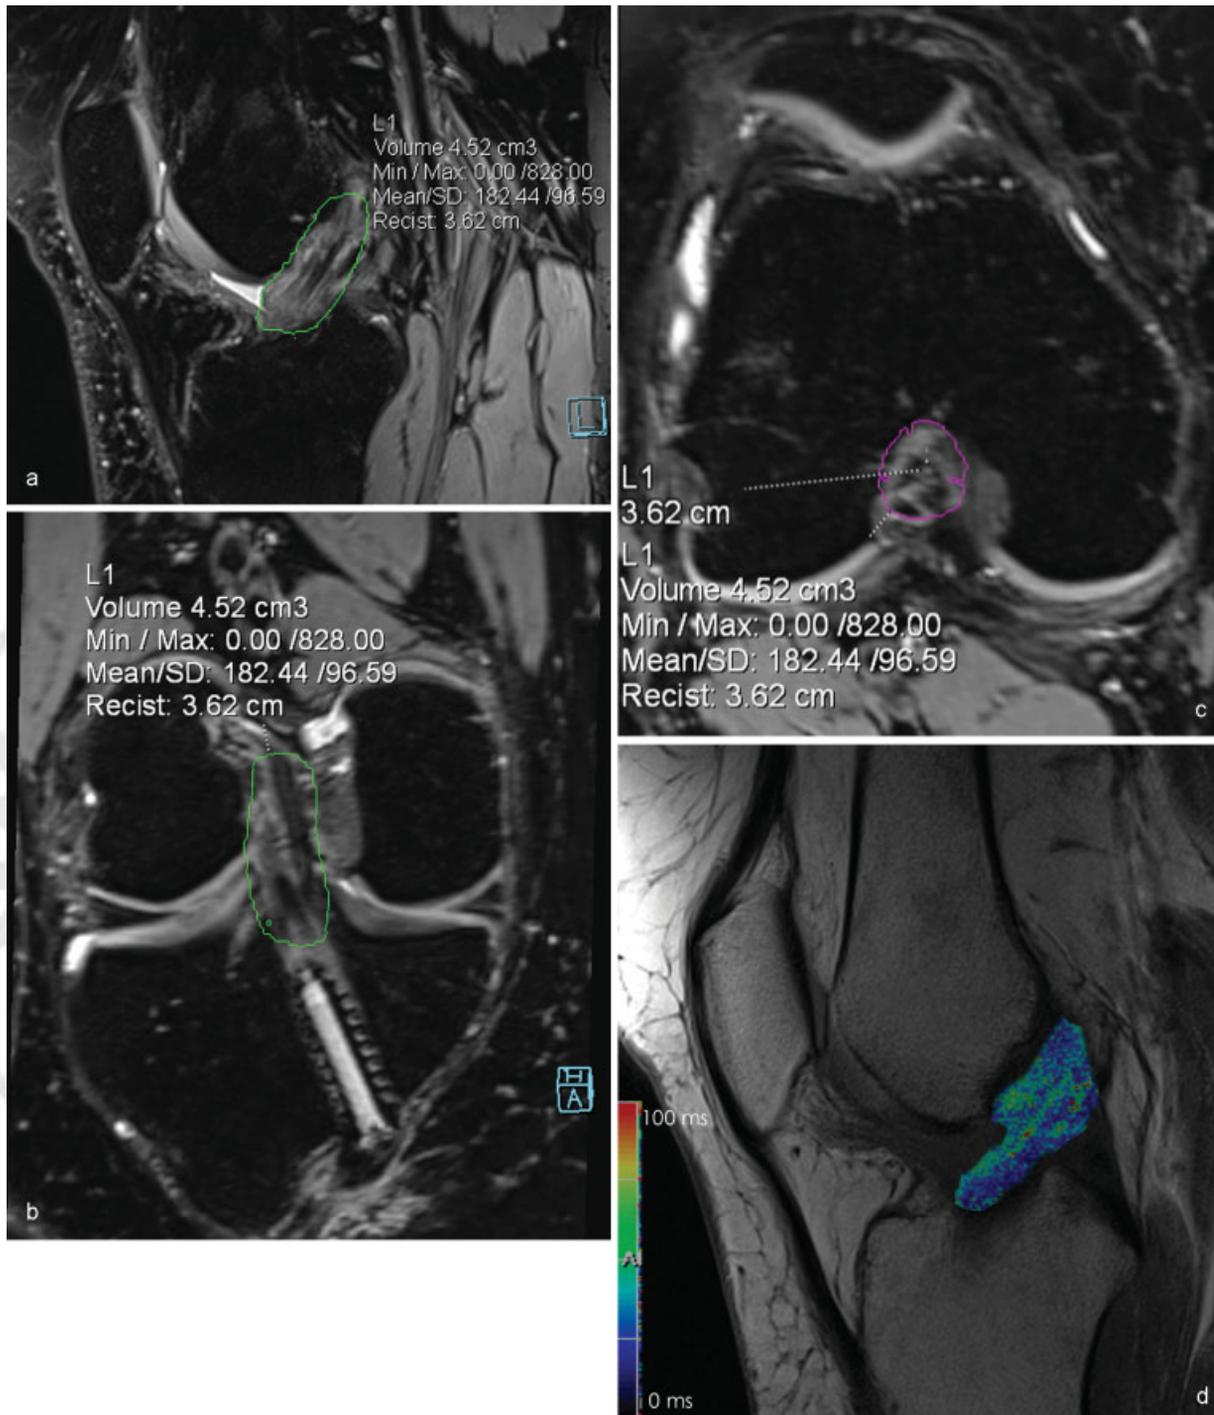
MRI-based volume measurements and quantitative T2 mapping of anterior cruciate ligament (ACL) graft in clinically stable knee. (a) Sagittal, (b) coronal, and (c) axial three-dimensional fs turbo spin-echo images showing volume measurements of intra-articular ACL graft. (d) Quantitative T2 mapping.
